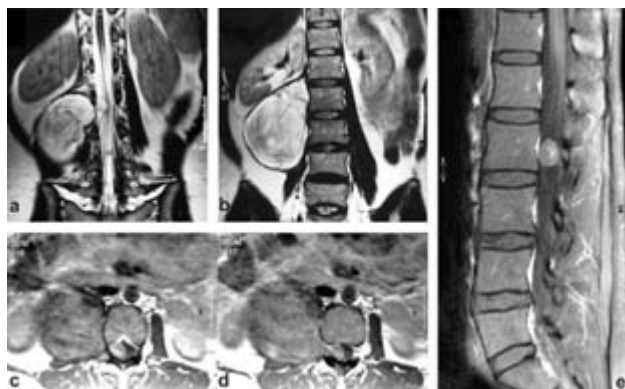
Coronal preoperative (a, b) T2-weighted MR-Images (TR 2700, TE 150) revealing the huge retroperitoneal and the intraspinal tumour. Axial, Gd-DTPA-enhanced T1-weighted MR-images (TR 944, TE 12) showing an extensive paraspinal and intraspinal plexiform neuro-fibroma (c, d). Sagittal (e) Gd-DTPA enhanced T1-weighted MR-images (TR 585, TE 12) exhibit an intraspinal tumour at the level of L2.
